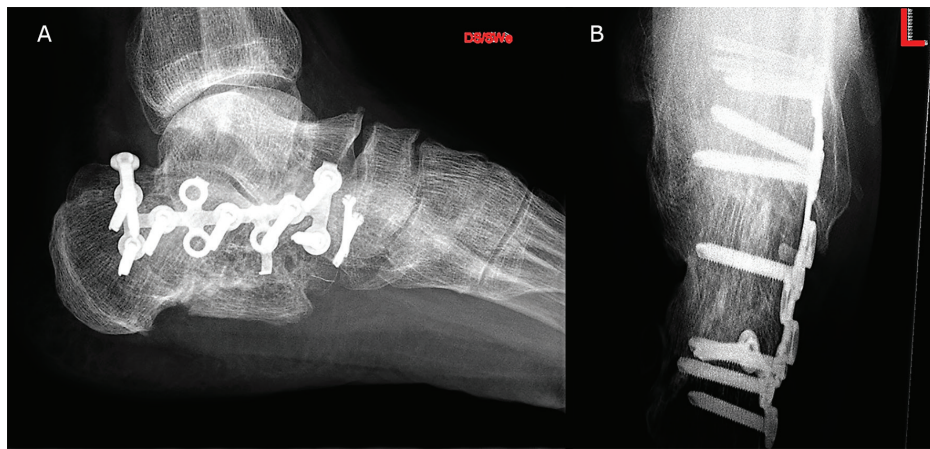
The lateral (A) and axial (B) calcaneus radiographs are showing the plate fixation of the calcaneus 10-month post-surgery.
